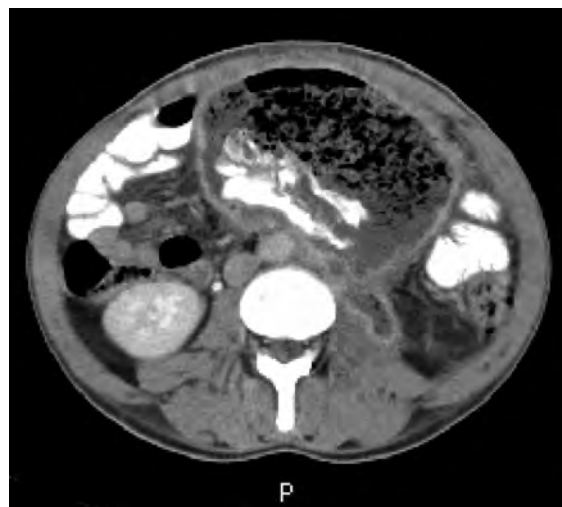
CT abdomen shows air fluid level with contrast in the abdominal mass with areas of solid component
